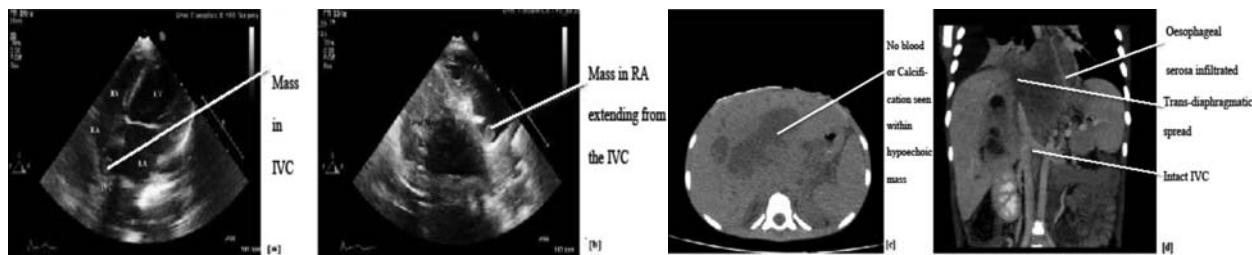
(a) 2-D Echocardiography (modified 4 chamber view) showing mass in IVC (b) Modified subcostal view with mass clearly seen in RA (c) CT: Nature of disease seen here – hypoechoic lesion with no blood/calcification within, unlikely to be carcinoma (d) Venous Phase of Triphasic CT: Trans diaphragmatic spread seen into the adjoining tissue, oesophageal serosa infiltrated. IVC, inferior vena cava; RA, right atrium; CT, computed tomography.
